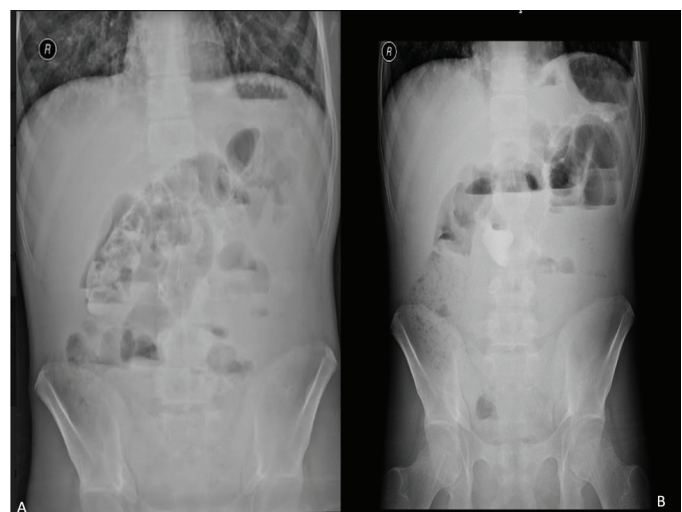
A) Direct abdominal radiography of a 10-year-old patient with distal intestinal obstruction syndrome diagnosis and B) Direct abdominal radiography of a 17-year-old patient with distal intestinal obstruction syndrome diagnosis before laparotomy
